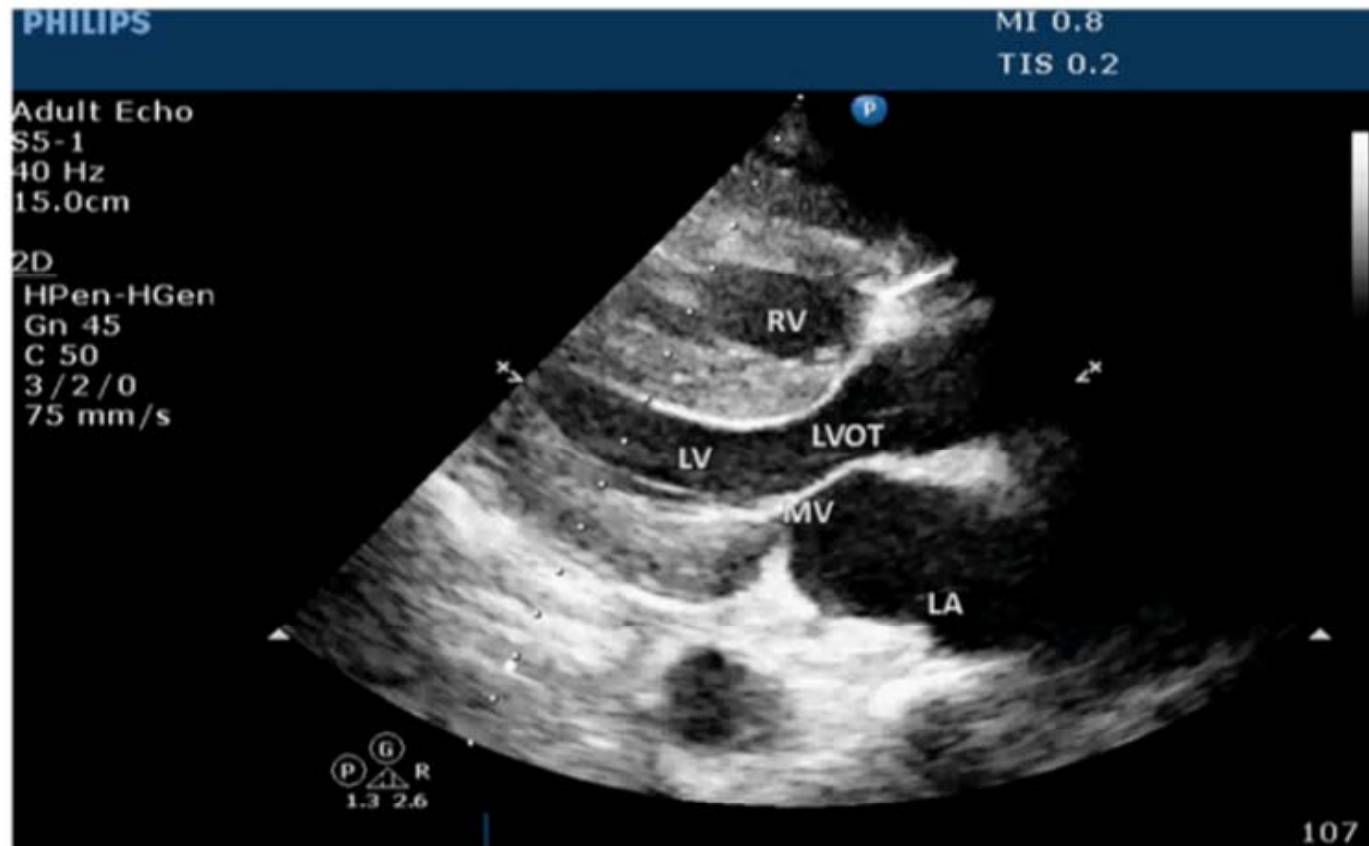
Parasternal long-axis view of the left atrium (LA), left ventricle (LV), mitral valve (MV), and left ventricle outflow tract (LVOT) during ventricular systole. BPM = beats per minute; RV = right ventricle.
